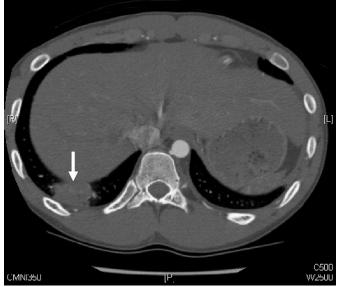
Computed tomography angiogram demonstrating left lower lobe infarction.
